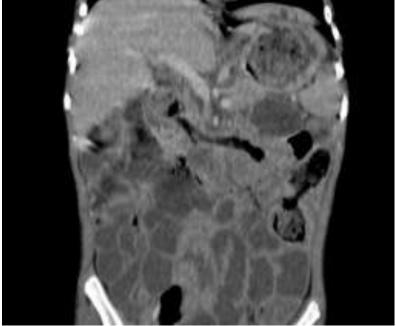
Axial (a) without injection and axial (b) and coronal (c) CT sections with injection of contrast product: heterogeneous gastric endoluminal mass extending to the jejunum, containing air bubbles similar to the digestive contents.
